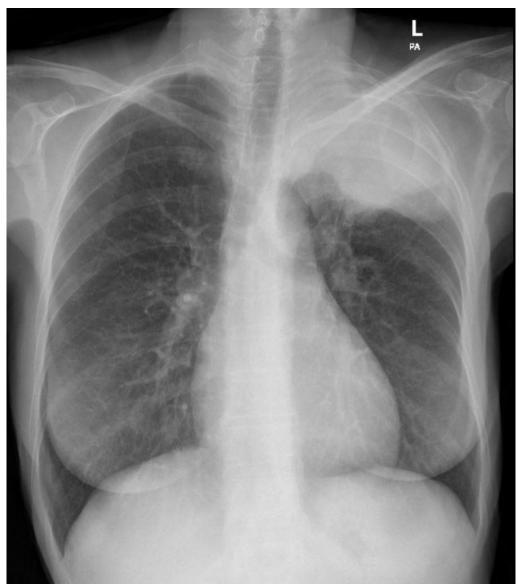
Chest X-Ray revealed opacity in the left upper lung zone
